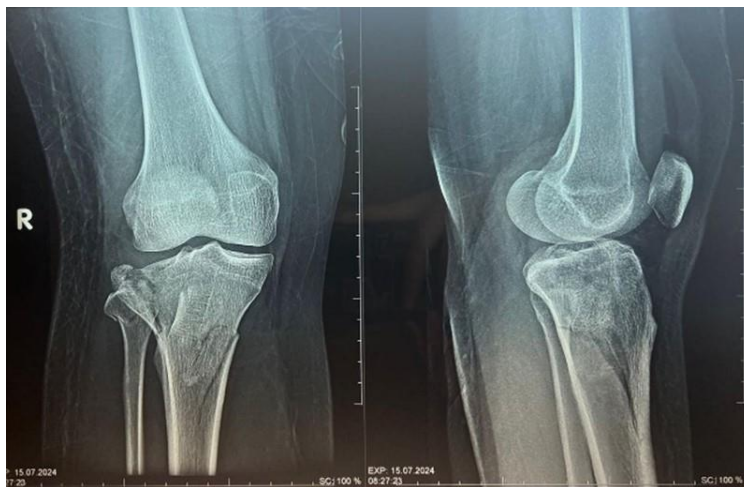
Radiographs show right tibial plateau fracture Schatzker type VI
